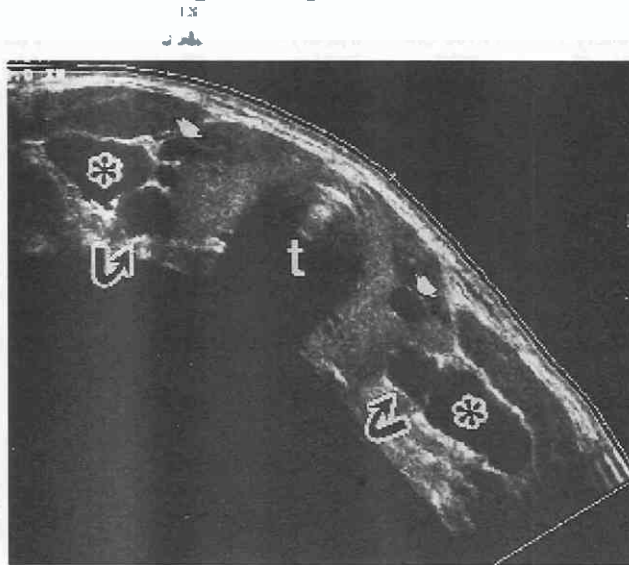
Transverse sonogram of the thyroid performed with an extended field of view (Siescape [Siemens]) shows the entire thyroid and adjacent structures. The right and left lobes are separated by the trachea (t). The isthmus lies superficial to the trachea. Simple cysts (arrows) are seen in the right and left lobes, which are otherwise normal. Curved arrows indicate common carotid arteries; asterisks show internal jugular veins.
